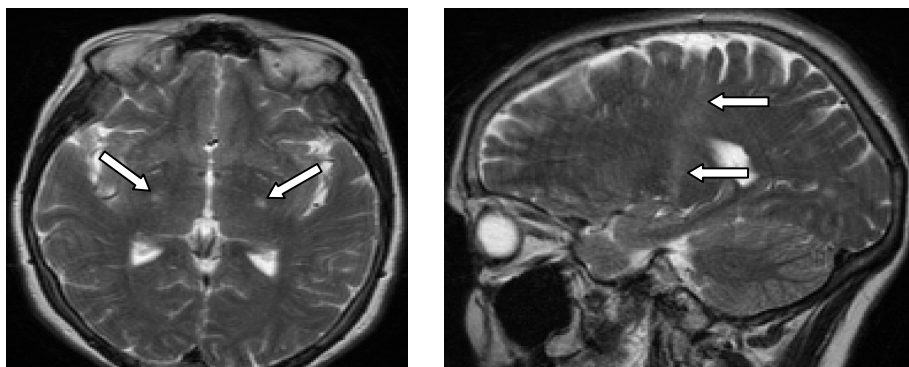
Routine MR imaging, T2-weighted axial (left) and sagittal (right) MR brain images show corticospinal tract hyperintensity (arrows) in a UMN-predominant ALS patient
